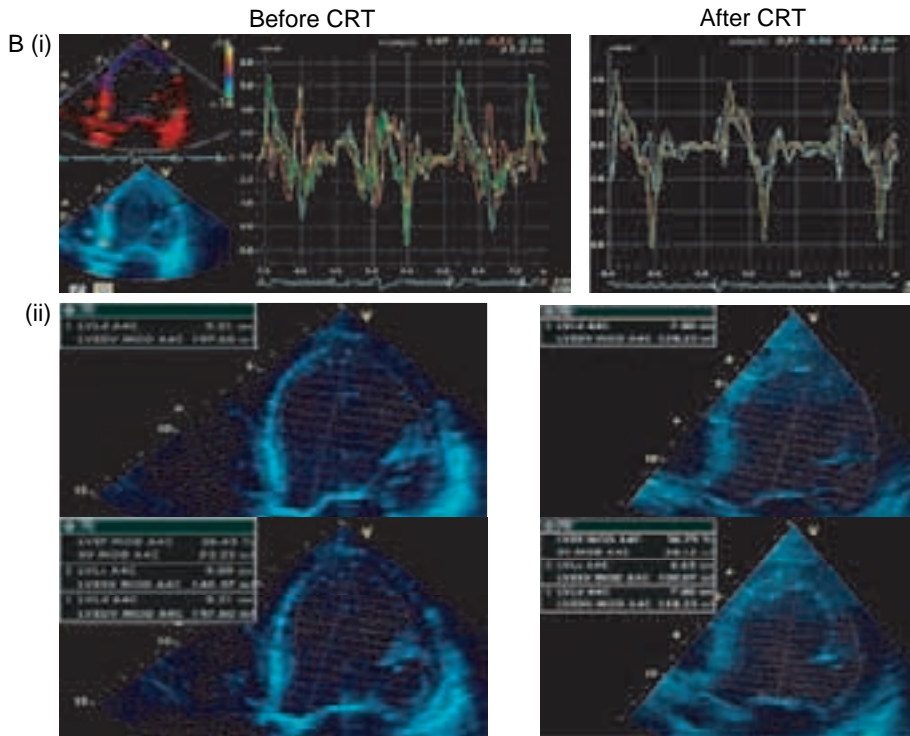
(Continued) (B) Tissue Doppler imaging (i) obtained in the basal and middle segments of the interventricular septum and the posterolateral wall of a patient with interventricular dyssynchrony before and after cardiac resynchronisation therapy (CRT). Note the severe dyssynchrony before CRT tracings and normalization of contraction synchrony after implantation of a CRT device. Note also that LV end-diastolic volume has decreased from 197 to 158 ml and that ejection fraction has increased from 20 to 37% (ii).
